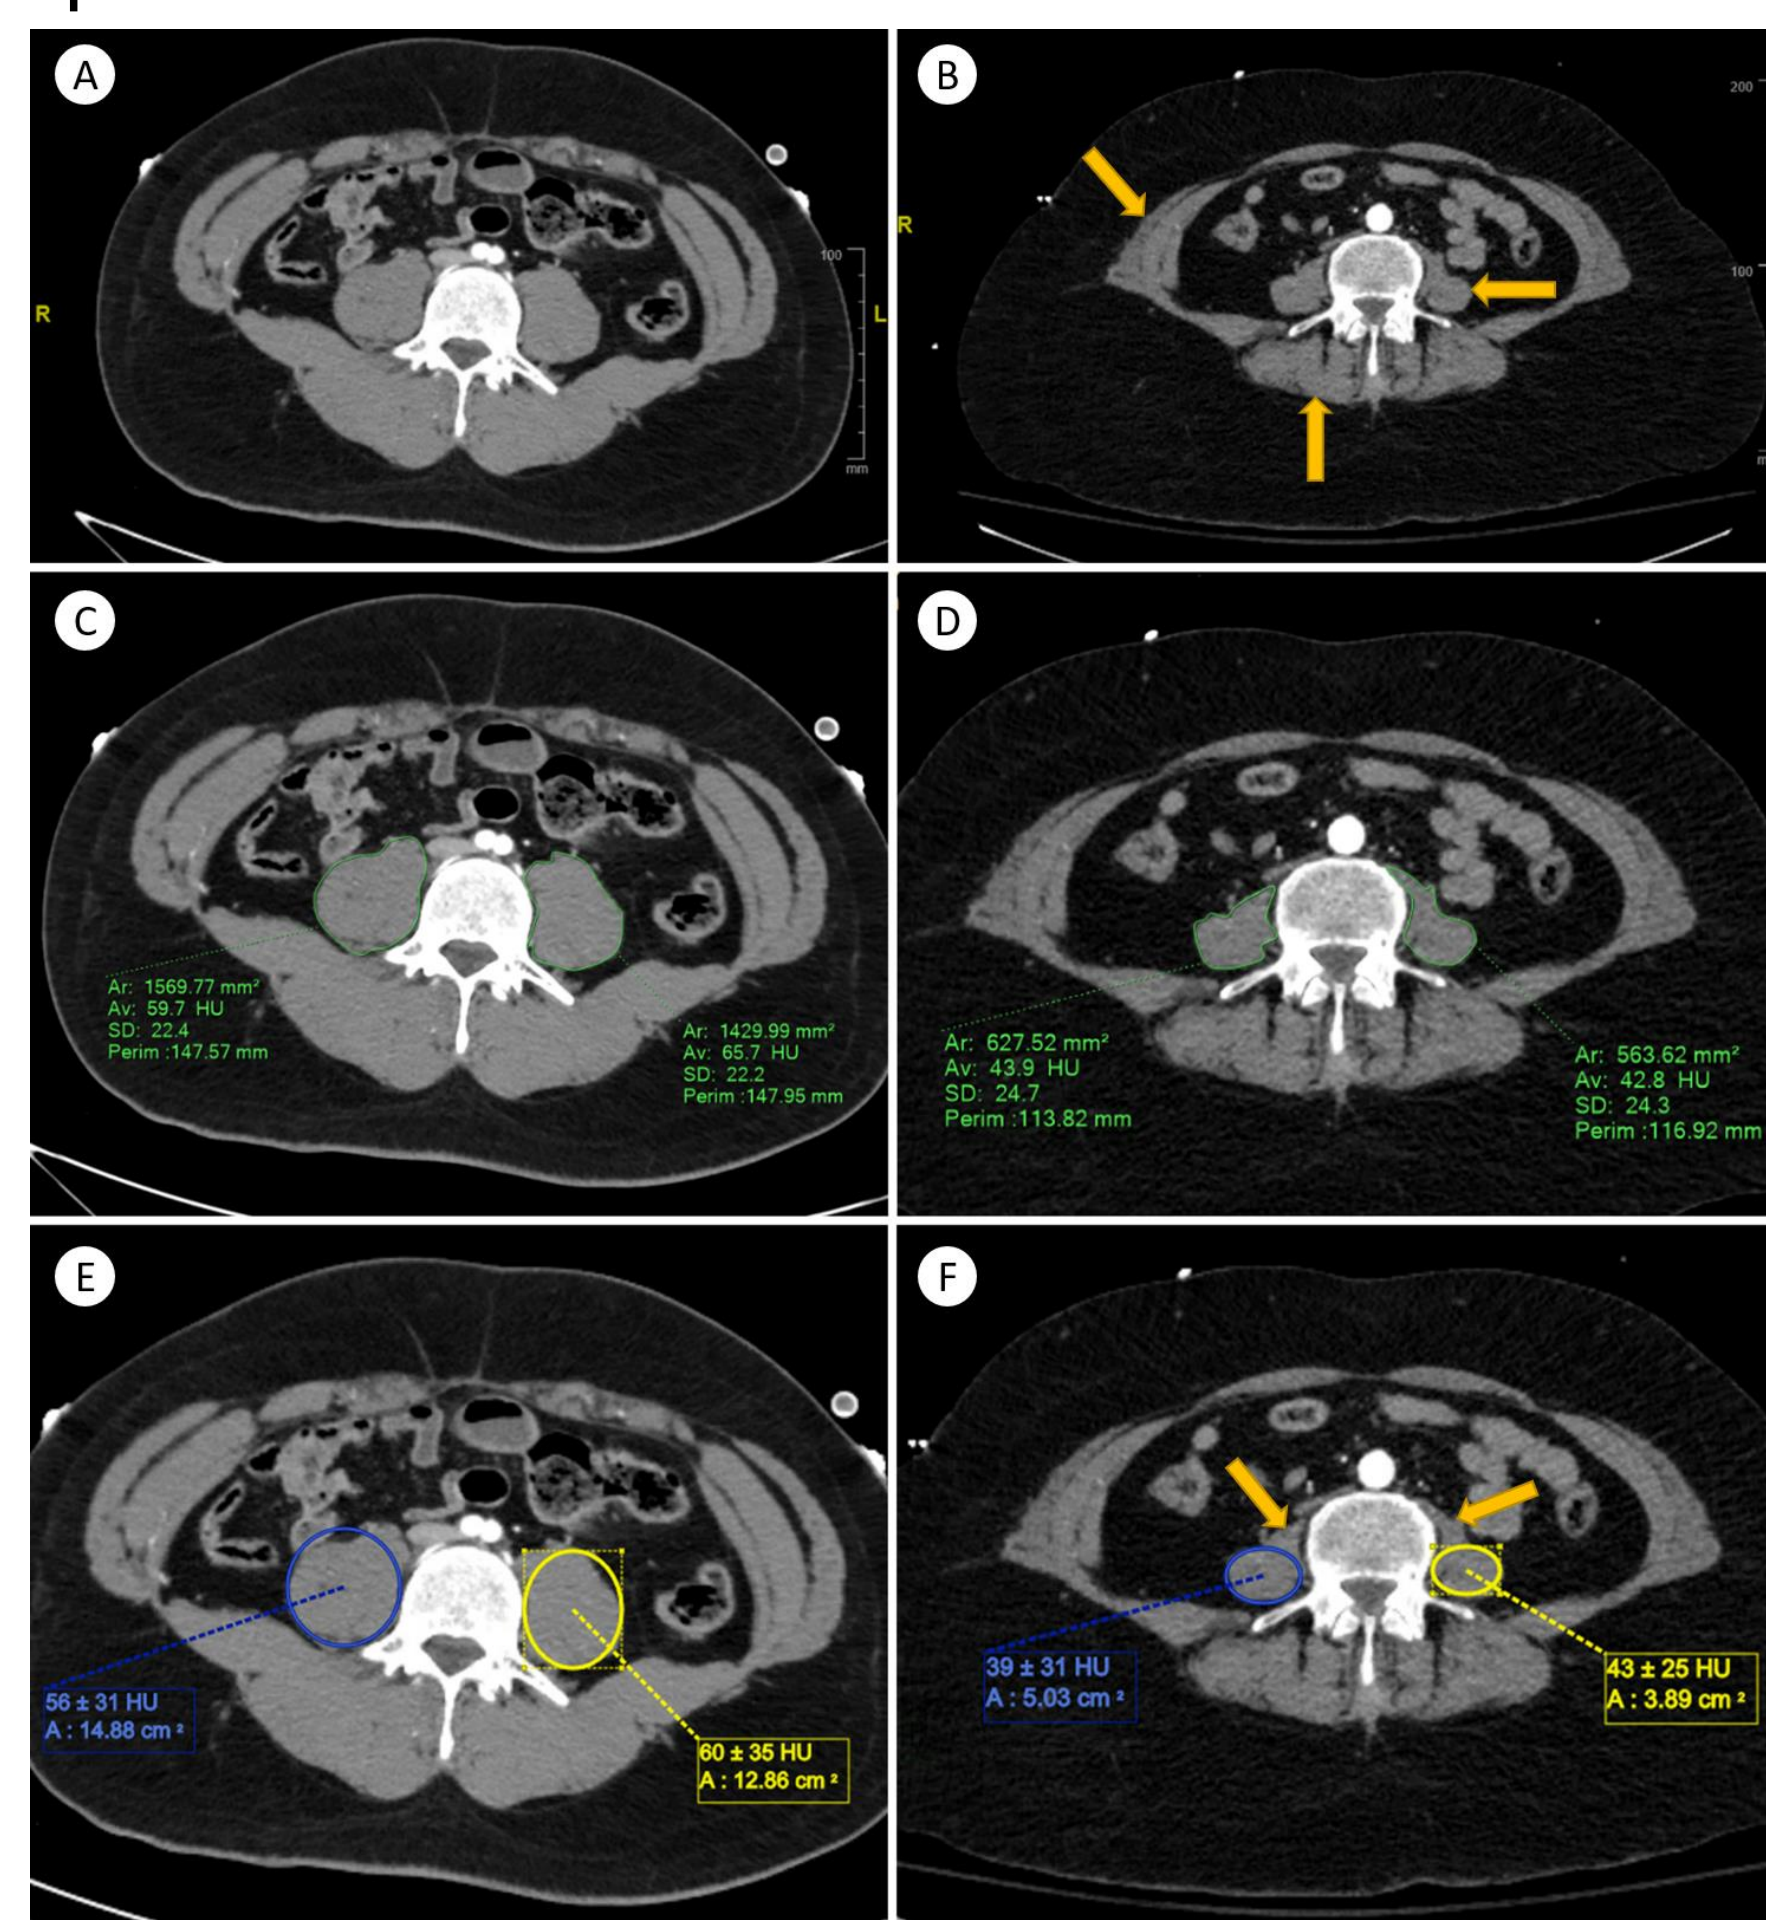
Assessment of Housfield unit average calculation (HUAC) in a non-sarcopenic (A/C/E) and sarcopenic (B/D/F) patient via the traditional HUAC (C/D) and ellipse (E/F) methods. (A/B) CT at the L4 spinal level demonstrating substantially less skeletal muscle mass and greater fatty infiltration (arrows) in the sarcopenic patient (B) relative to the non-sarcopenic patient (A).
